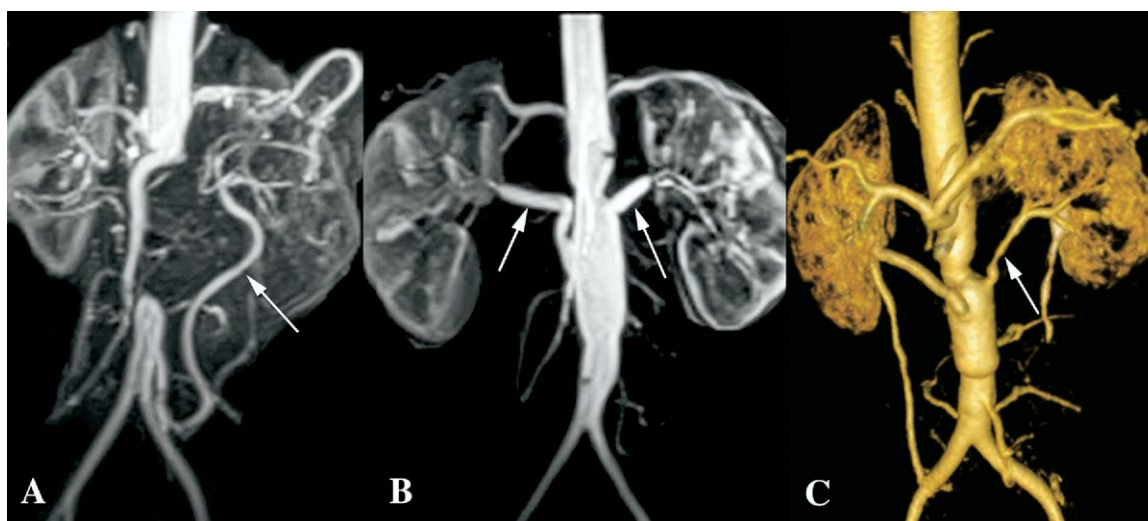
A, Preoperative magnetic resonance imaging-angiography (patient 9) showing complete occlusion of a long segment of the infrarenal aorta and perfusion of the distal aorta through Riolan's arcade and the inferior mesenteric artery. B, Postoperative magnetic resonance imaging-angiography at 6 months showing patency of the abdominal aortic homograft and the 2 renal artery homografts without signs of restenosis or graft degeneration. C, Postoperative magnetic resonance imaging-angiography at 5 years showing aneurysmal dilatation of the abdominal aortic homograft with diffuse stenosis of the left renal homograft artery.
